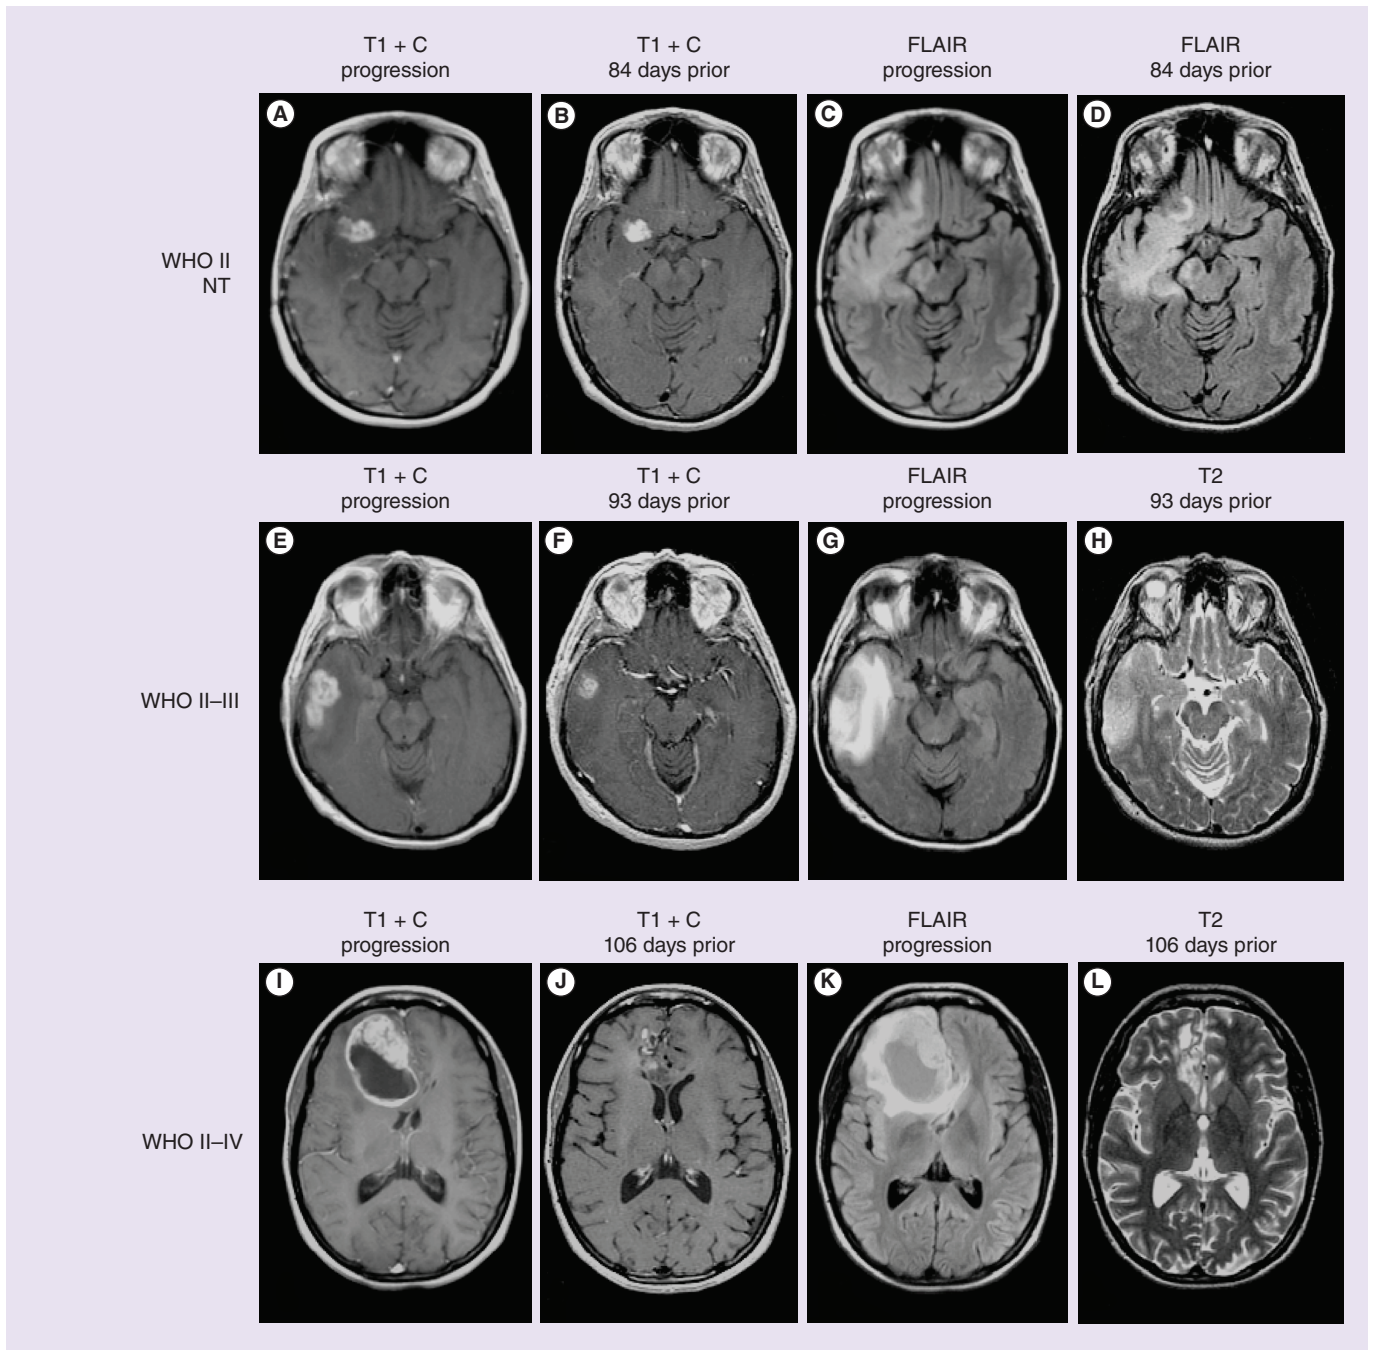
Examples of contrast-enhancing diffuse astrocytomas. (A–D) WHO II diffuse astrocytomas that did not transform (nontransforming). (A) Postcontrast T1-weighted image at radiographic progression. (B) Postcontrast T1-weighted image at previous imaging time point, 84 days prior to progression. (C) T2-weighted FLAIR image at radiographic progression. (D) T2-weighted FLAIR image 84 days prior to progression. (E–H) WHO II diffuse astrocytomas that transformed to WHO III anaplastic astrocytomas. (E) Postcontrast T1-weighted image at radiographic progression and malignant transformation. (F) Postcontrast T1-weighted image at previous time point, 93 days prior to radiographic progression. (G) T2-weighted FLAIR image at the time of progression and malignant transformation. (H) T2-weighted image 93 days prior to radiographic progression and malignant transformation. (I–L) WHO II diffuse astrocytomas that transformed to WHO IV glioblastoma. (I) Postcontrast T1-weighted image at radiographic progression and malignant transformation to glioblastoma. (J) Postcontrast T1-weighted image 106 days prior to recurrence and malignant transformation. (K) T2-weighted FLAIR images at progression and (L) T2-weighted image 106 days prior to recurrence and transformation. FLAIR: Fluid-attenuated inversion recovery; NT: Nontransforming.
